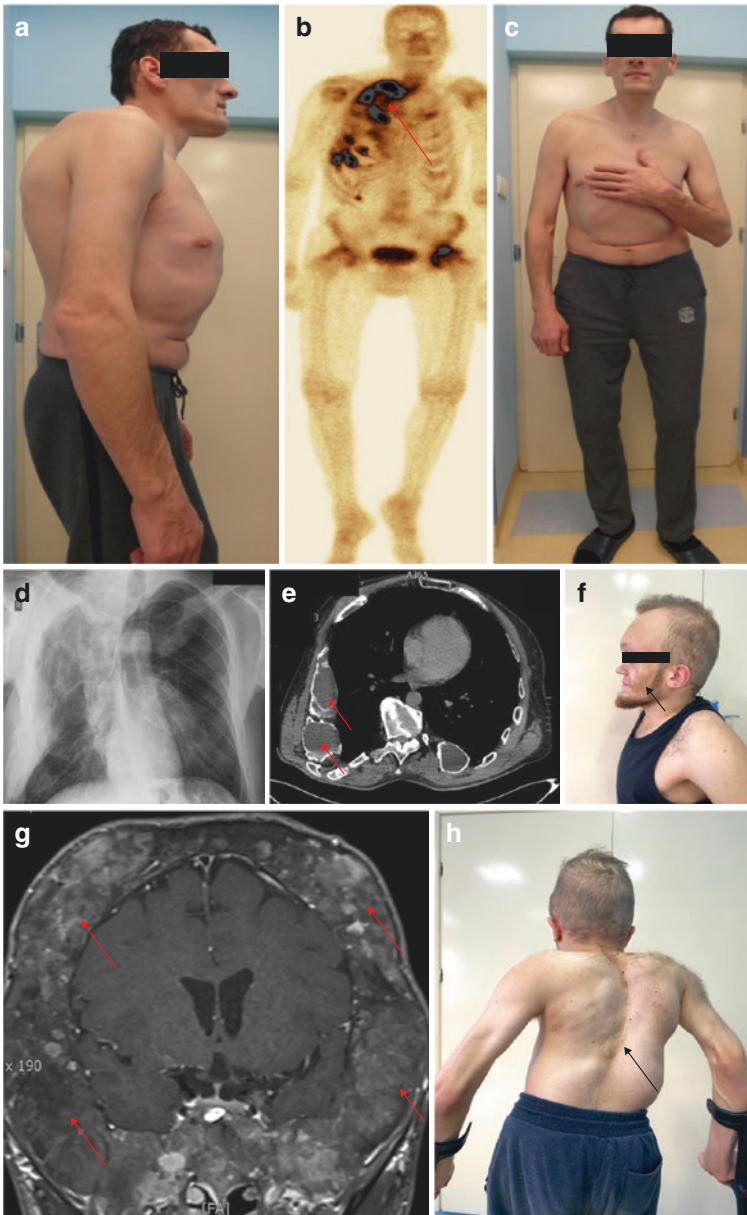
(a–e) Clinical presentation of a patient with McCune-Albright syndrome with tall stature: (a) deformity of the thorax and acromegalic facial features; (b) extensive and asymmetric fibrous dysplasia in the right ribs in bone scintigraphy; (c) acromegalic features in McCune-Albright syndrome: tall stature (192 cm), hand enlargement; (d) skeletal deformity in chest radiography; (e) fibrous dysplasia in CT scan. (f–h) Clinical presentation of an adult patient with McCune-Albright syndrome with precocious puberty and GH excess: (f) cafe au lait spots on the face, (g) fibrous dysplasia involving skull base, (h) skeletal deformity, cafe au lait spots. Courtesy of Prof. Wojciech Zgliczyński and Dr. Maria Stelmachowska-Banaś, Department of Endocrinology, Bielański Hospital, Warsaw, Poland
